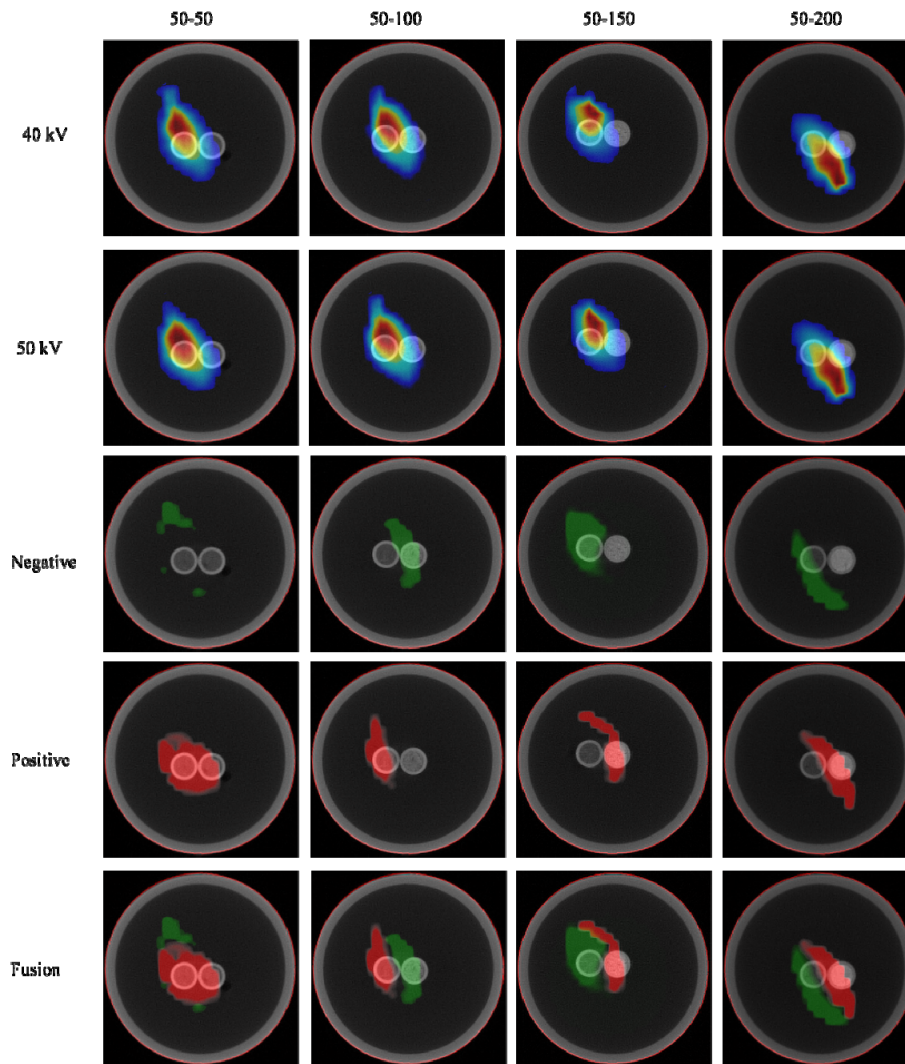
Tomographic ($z = 1.1$ cm) results of the third experiment. The first two rows show the tomographic reconstruction results corresponding to each excitation X-ray tube voltage obtained by the ART algorithm. The last three rows show the PCs of each case obtained by PCA. The green parts indicate the negative PC2 and the red parts indicate the positive PC2.
